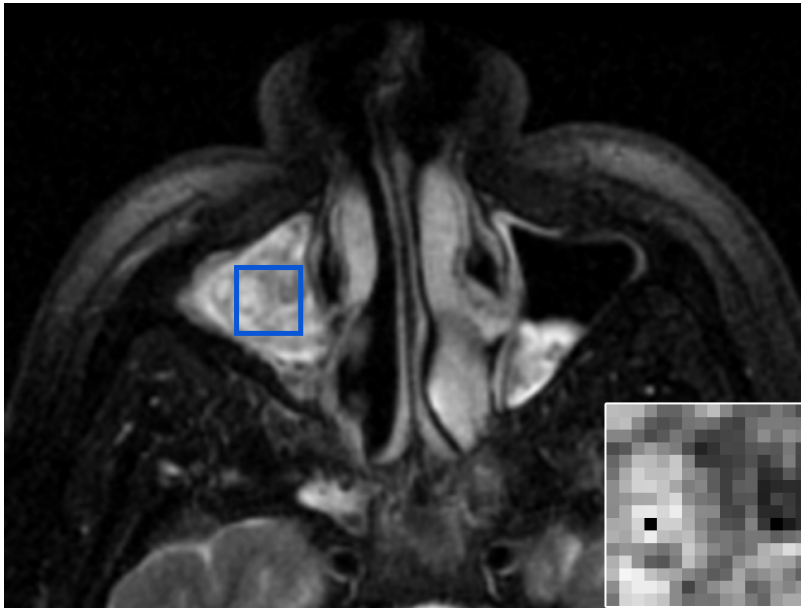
ROI placement. A 51-year-old man with an IP involving the right maxillary sinus. Axial T2-weighted fat-suppressed MR imaging pulse sequence demonstrates the manual placement of the largest rectangular ROI that would fit within the tumor margins on the axial image with the greatest tumor cross-sectional area. The inset image in the lower right corner is representative of the final 16x16 matrix that was derived from the ROI isocenter and served as the input for texture analysis.
